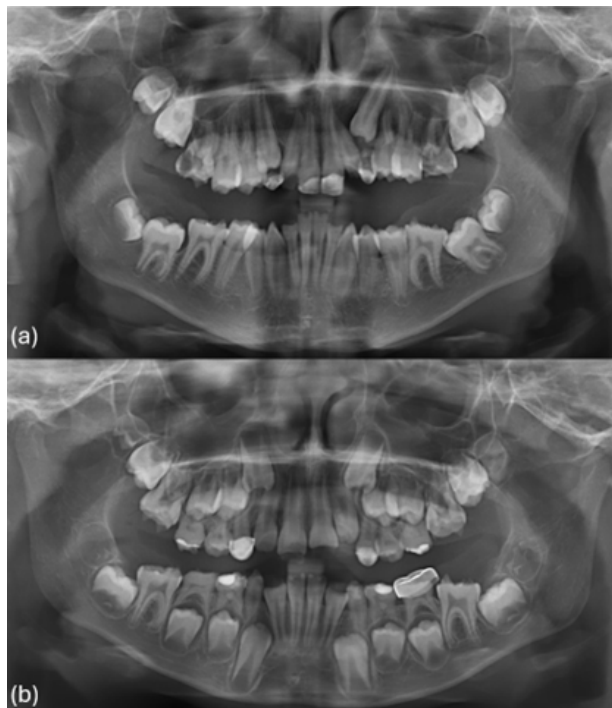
(a) Orthopantomogram taken in 2022, (b) Orthopantomogram taken in 2018.
